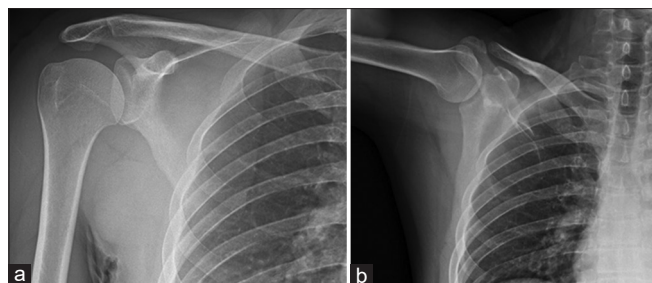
X-ray view of the right shoulder. (a) anterior anatomical position, (b) semiabduction position
